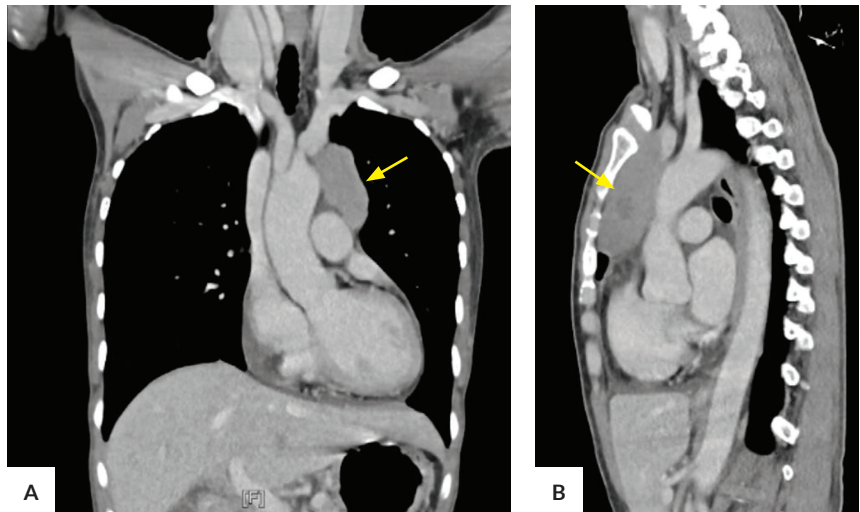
CT scan showing mediastinal anterior mass (yellow arrows).
